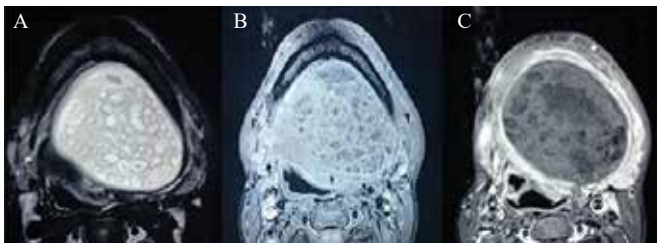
(A) Axial T2-weighted images show cystic hyperintense mass with sack of marbles (coalescence of fat into the small nodules) in the floor of the mouth. (B) Axial T1-weighted images show isohypointense cystic mass in the mouth base. (C) Gadolinium-enhanced axial T1-weighted images show cystic mass with peripheral rim-like contrast enhanced.
